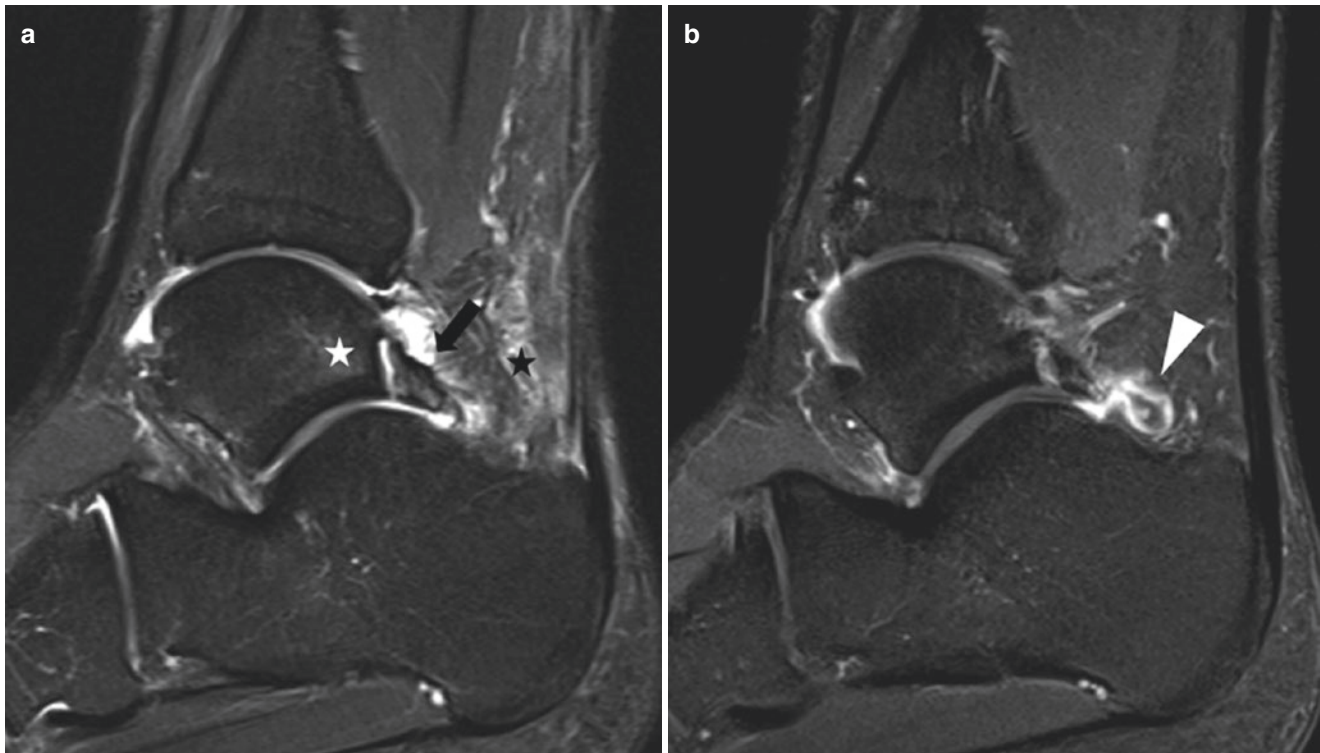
Posterior ankle impingement (os trigonum syndrome). Sagittal fat-suppressed intermediate weighted MR image of the ankle (a) demonstrates os trigonum with bone marrow edema separated from the talus by interposed fluid (*black arrow*), bone marrow edema in the posterior talus (*white star*), and retroachillear soft tissue edema (*black*
